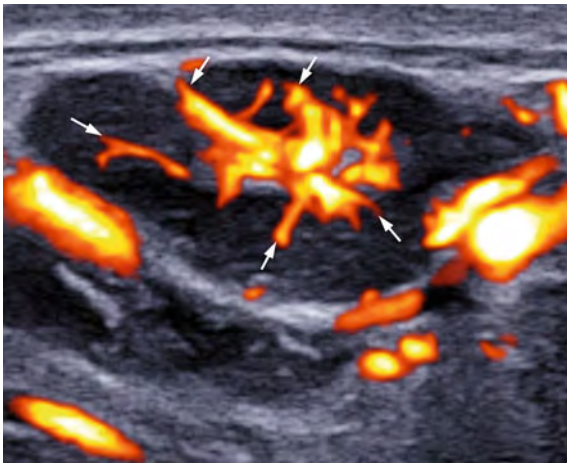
Grey scale US with power Doppler showing a prominent reactive submandibular lymph node with florid hilar vascularity (arrows)
